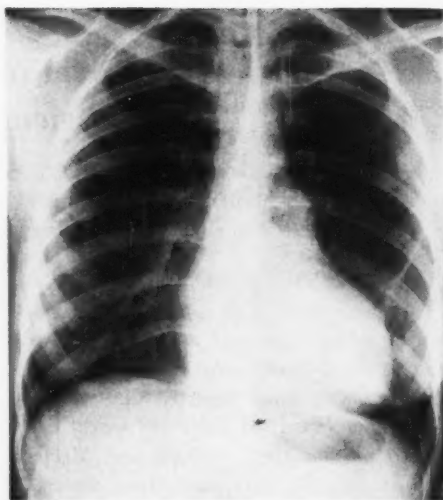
X-ray showing unusual contour with prominence of left ventricle and pulmonary artery.
